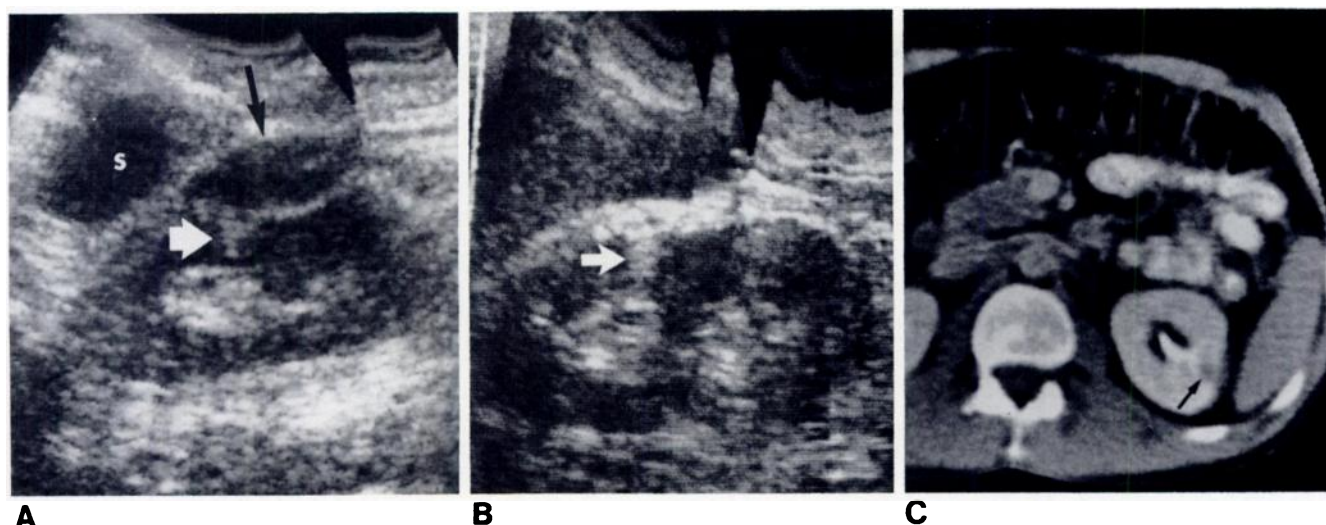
35-year-old man with left flank pain and hematuria. A, Initial coronal sonogram of left kidney. Subcapsular hematoma (black arrow). Small angiomyolipoma (white arrow) was not appreciated on this study at this time.
